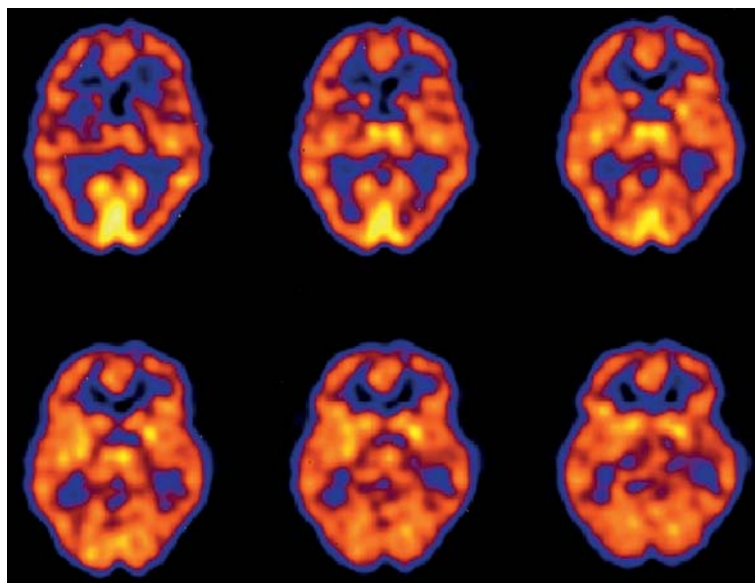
Transaxial SPECT images of ^{99m}Tc bicusate in a patient with depression show overall decreased perfusion in the cortex, with the frontal lobes most prominently affected. There is preserved perfusion in the visual cortex and thalamus.
